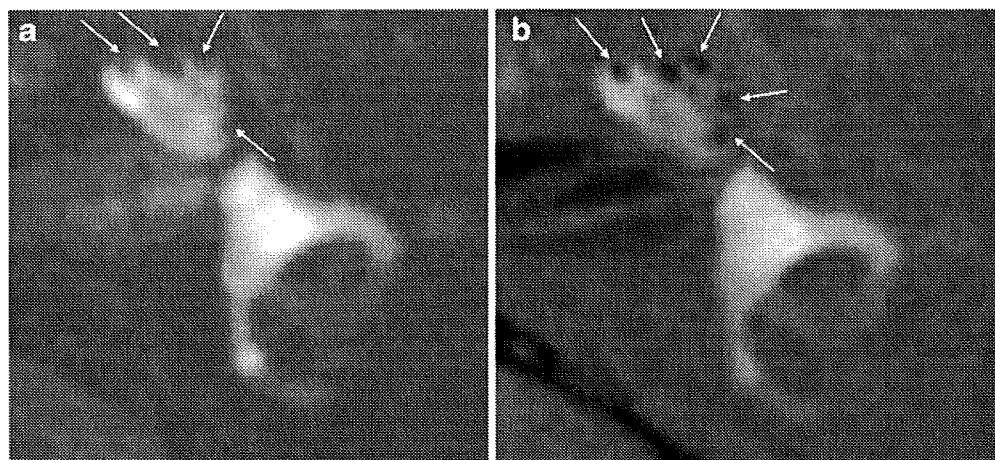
A 33-year-old man with delayed endolymphatic hydrops. All images were obtained 24 h after the intratympanic injection of Gd-DTPA. (a) 3D-FLAIR (9,000/134/2,500) shows enlarged endolymphatic space in the cochlea (arrows), but not in the vestibule. The boundary between endolymphatic space and surrounding bone is unclear. (b) A 3D-real IR sequence (9,000/134/1,700) visualizes severely enlarged endolymphatic space in all cochlear turns (arrows)
